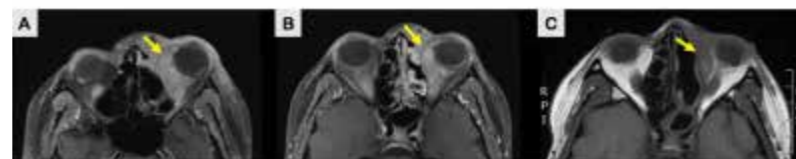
T1 Axial MRI images. A: Initial image on presentation. Arrow shows left medial orbital mass with adjacent sinus involvement. B: Image three days after starting steroids. Arrow shows reduced size of mass. C: Image two weeks after presentation showing further reduction in orbital mass.
